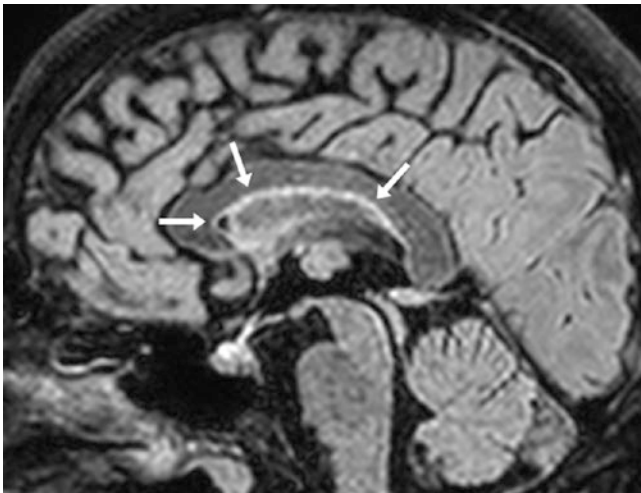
A 41 year old with normal hyperintensity (*arrows*) of the callosal-septal interface, which runs parallel to the corpus callosum on a midline three-dimensional acquired sagittal FLAIR image
